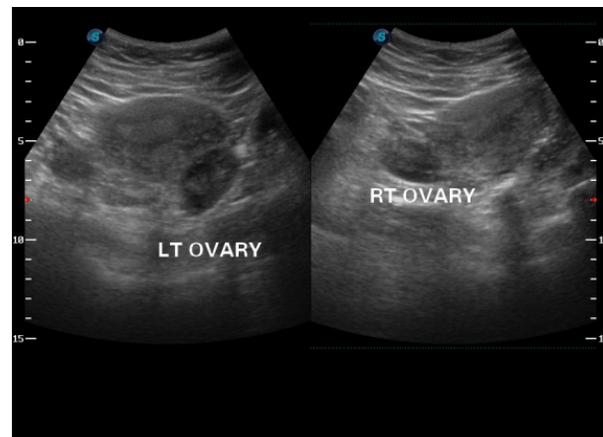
Transabdominal (TAS) ultrasound image not clearly showing Ovarian follicles in fertile group.
